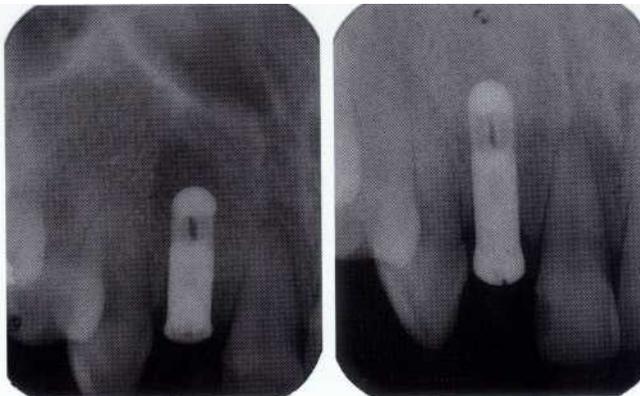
Radiographs of periapical lesion (left) and resolution of fistula (right), showing complete bone fill after periapical incision and drainage and apical debridement.
